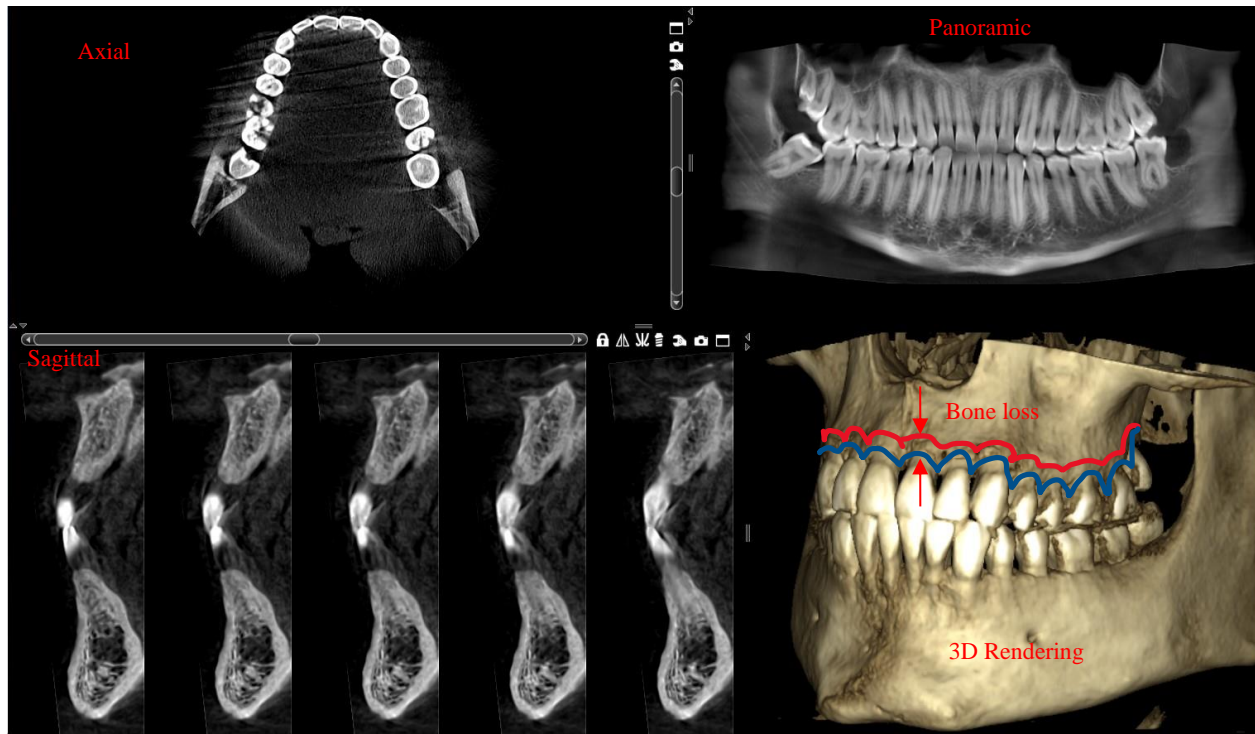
Imaging with different views using 3D CBCT.
